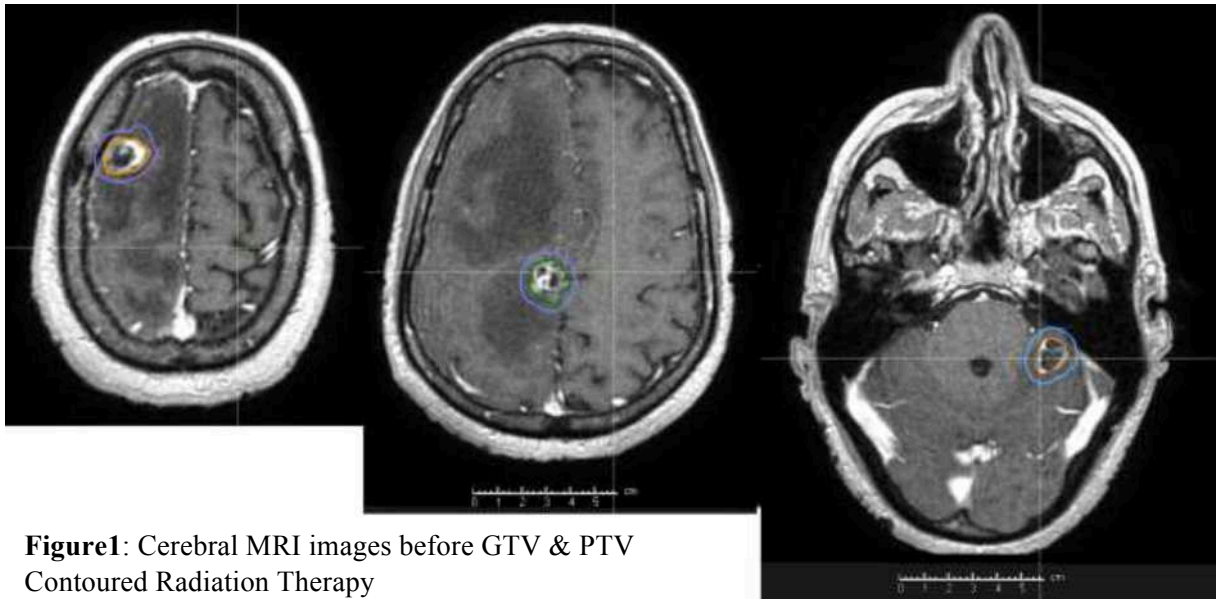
Cerebral MRI images before GTV & PTV Contoured Radiation Therapy
